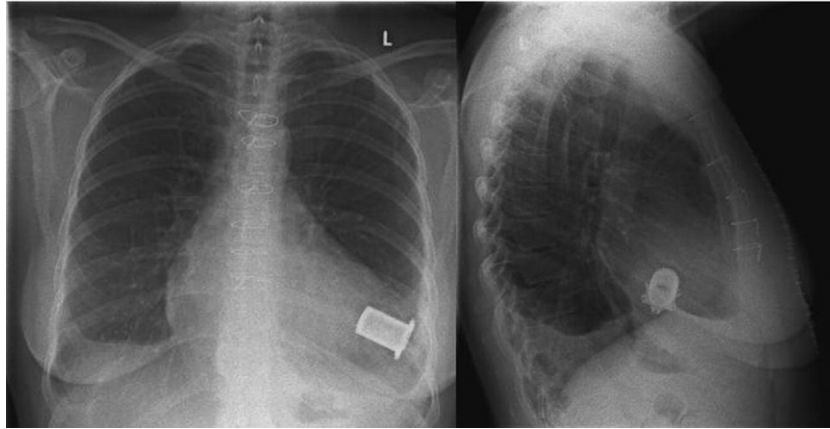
Postoperative X-ray with the plug in situ.
